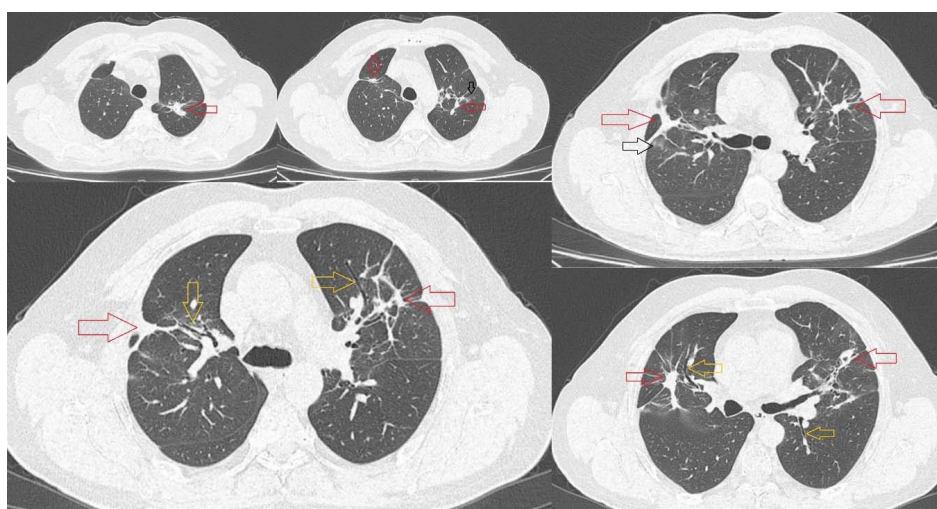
CT scan - Bilateral spiculated pseudonodular consolidations (red arrows), cylindrical bronchiectasis (yellow arrows), and minimal areas of ground-glass opacity adjacent (black arrows)
